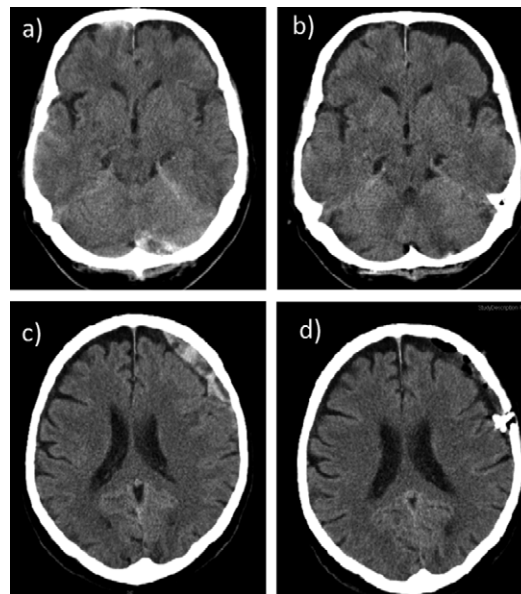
a) The initial CT scan shows contusions, SAH, and small SDHs; b) control CT scan shows a regression of the intracranial hemorrhage; c) control CT scan 3 weeks later shows a subacute SDH with thickness of 15 mm and mass effect; d) postoperative control CT scan.
